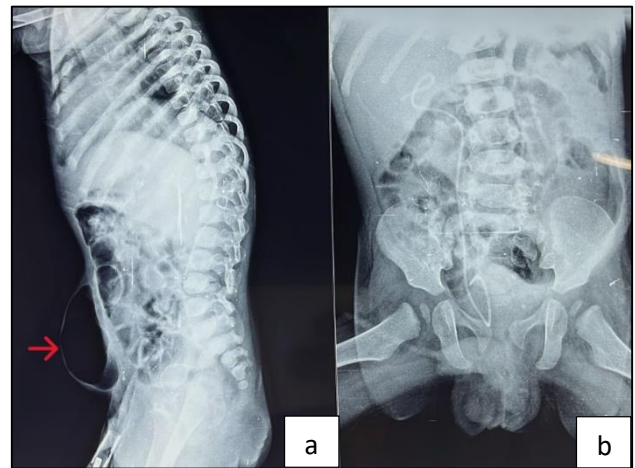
(a and b): Lateral abdominal X-ray showing distended bowel loops and subcutaneous emphysema (red arrow).
